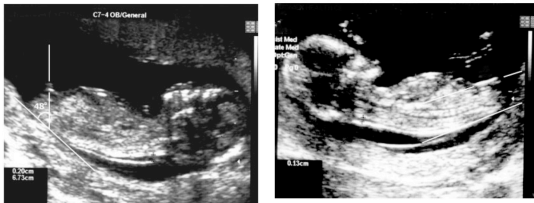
Male gender was assigned sonographically if the angle of the genital tubercle to a horizontal line through the lumbosacral skin surface was  $> 30^\circ$ .
